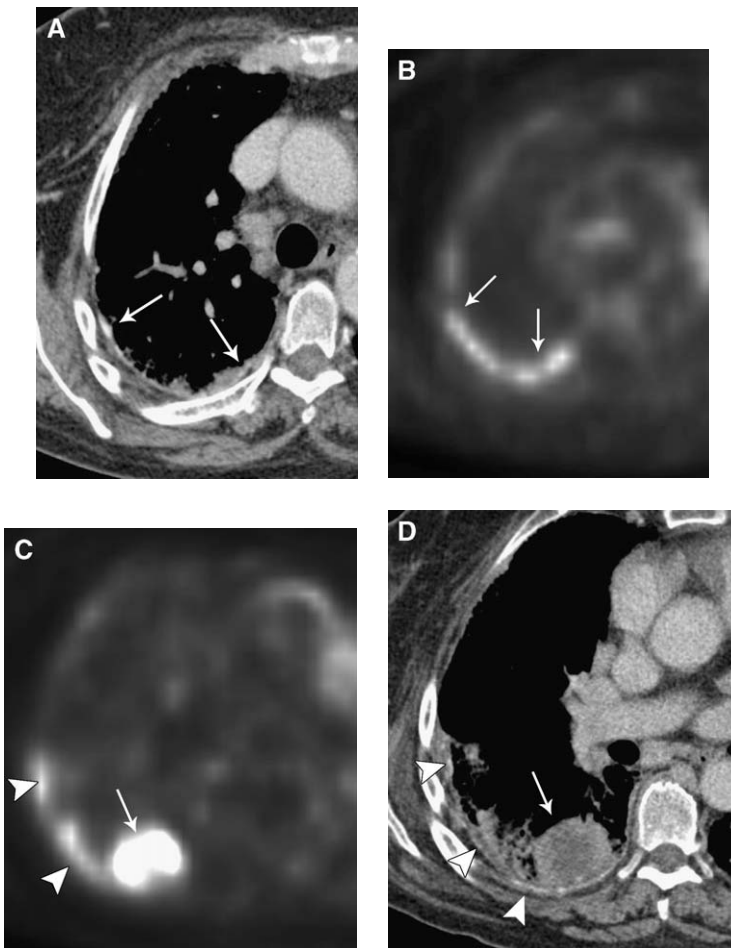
A 75-year-old woman with history of metastatic pleural disease and prior talc pleurodesis in the right thorax. (A) CT scan shows foci of increased attenuation consistent with talc deposits (arrows). (B) FDG-PET shows intense uptake in the pleural space in the same distribution as the talc deposits (arrows). (C) In the lower thorax there is a large focus of increased FDG uptake (arrow) adjacent to the linear pleural talc deposits (arrowheads). (D) CT shows a metastatic focus (arrow) and adjacent talc in the pleura (arrowheads).
